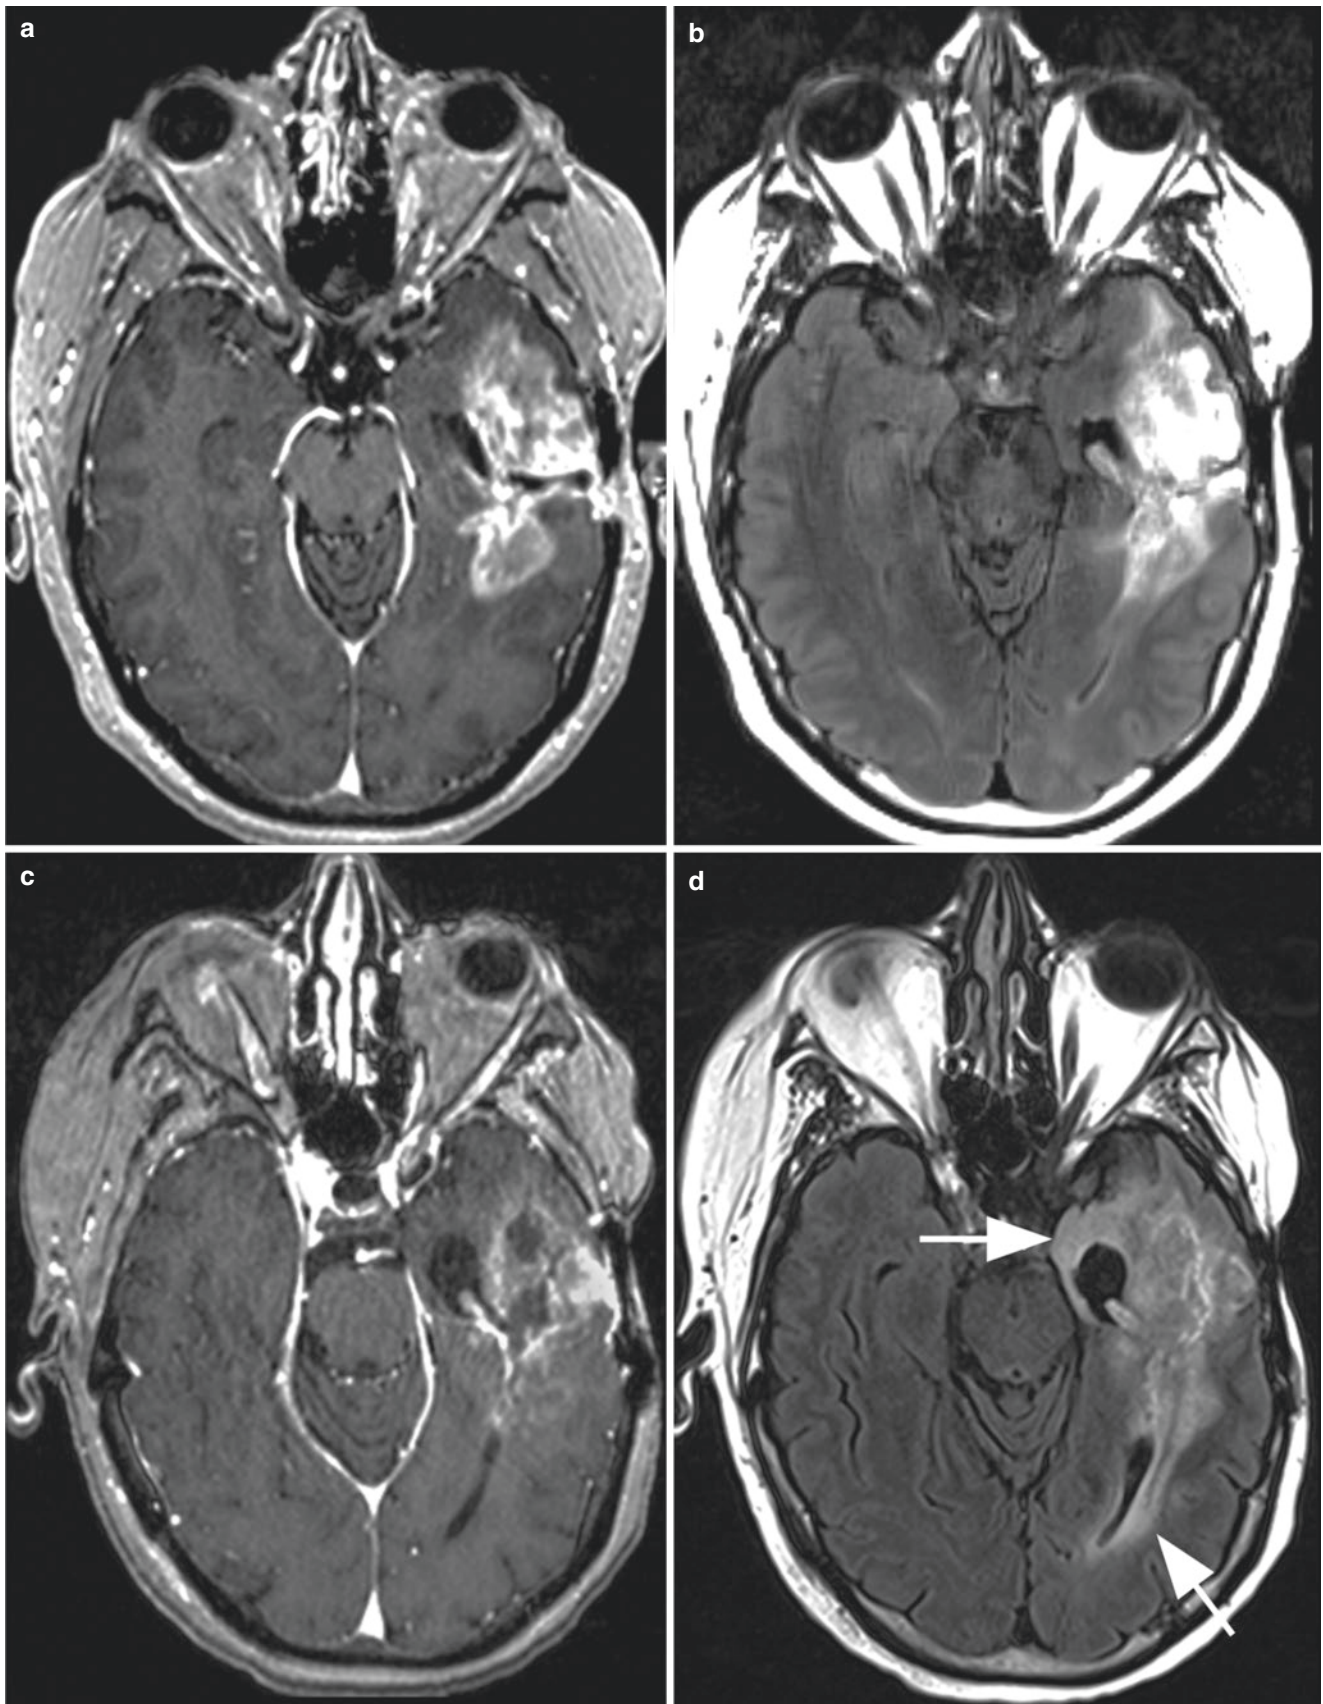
Pseudoprogression in a patient with glioblastoma. (a) The preoperative T1-weighted postcontrast MRI shows a large left frontal enhancing mass. Immediate postoperative precontrast (b) and postcontrast (c) images show no definite residual enhancing mass beyond postoperative blood products. (d) Three months into the start of radiation
